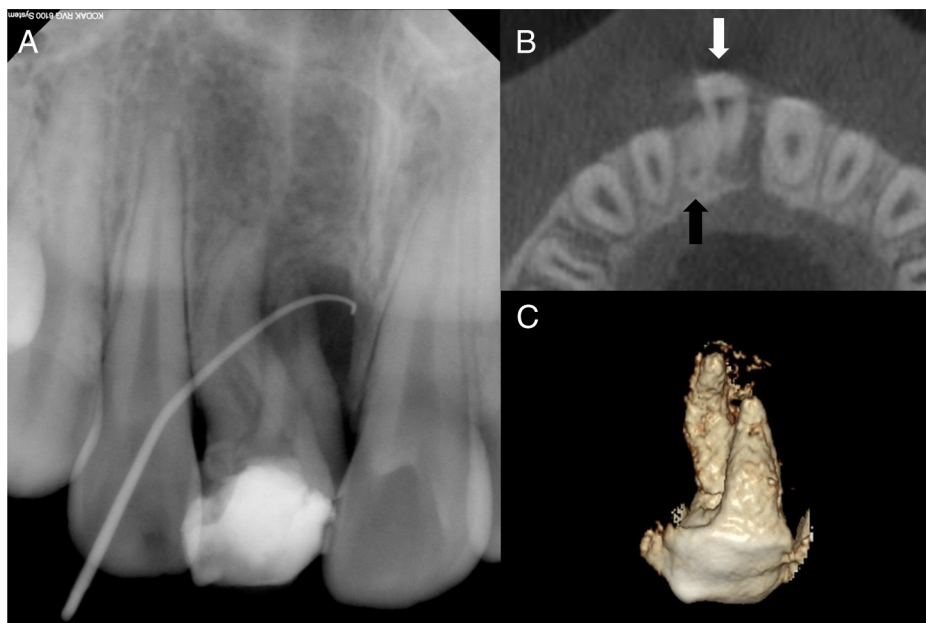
(A) A periapical radiograph of the maxillary right central incisor with gutta-percha tracing. (B) A reformatted axial view of the cone-beam computed tomographic scan of the maxillary right central incisor. The *white arrow* indicates the mesial root of the tooth, and the *black arrow* indicates the distal root of the tooth. (C) Three-dimensional reconstruction of the tooth.
